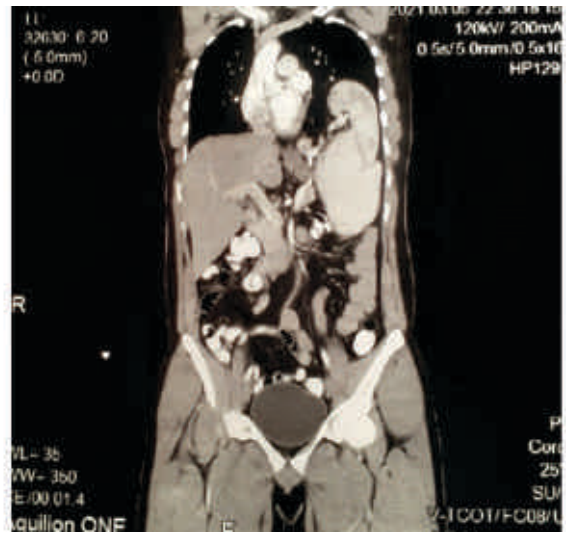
CT Scan Chest, Abdomen & Pelvis showing abdominal organs in thorax
